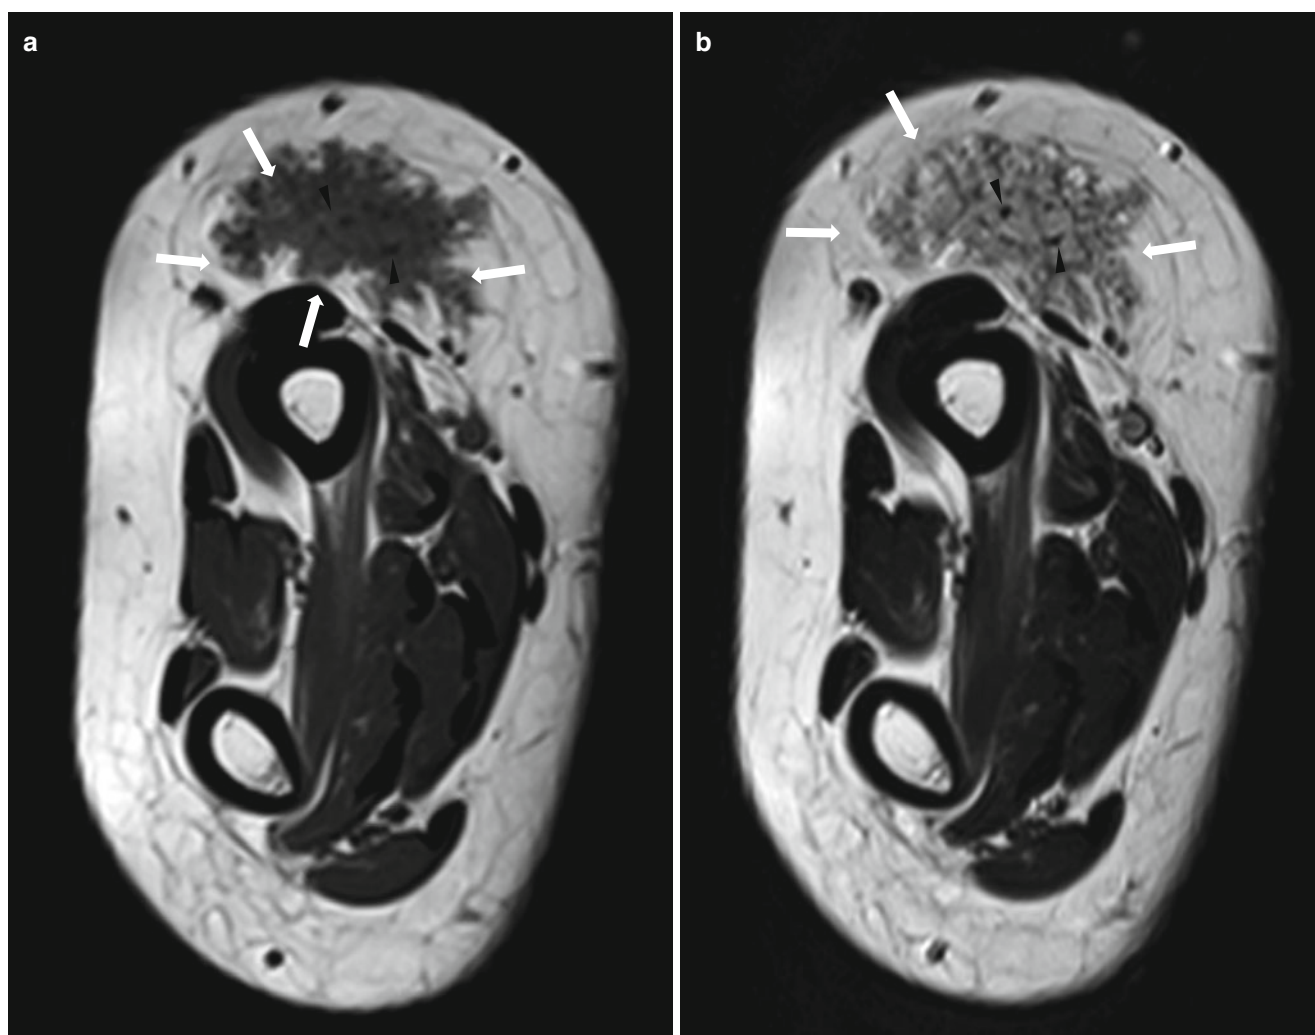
MR images of a 17-year-old female patient with arteriovenous malformation. (a) Axial T1-weighted MR image shows isointense tangled mass (arrows) in subcutaneous layer of distal forearm. (b) Axial T2-weighted MR image shows the mass (arrows) with slightly hyperintense signal intensity relative to muscle. (c) Axial T2-weighted fat-suppressed MR image shows the mass (arrows) with bright signal intensity. (d) Axial gadolinium-enhanced fat-suppressed T1-weighted
